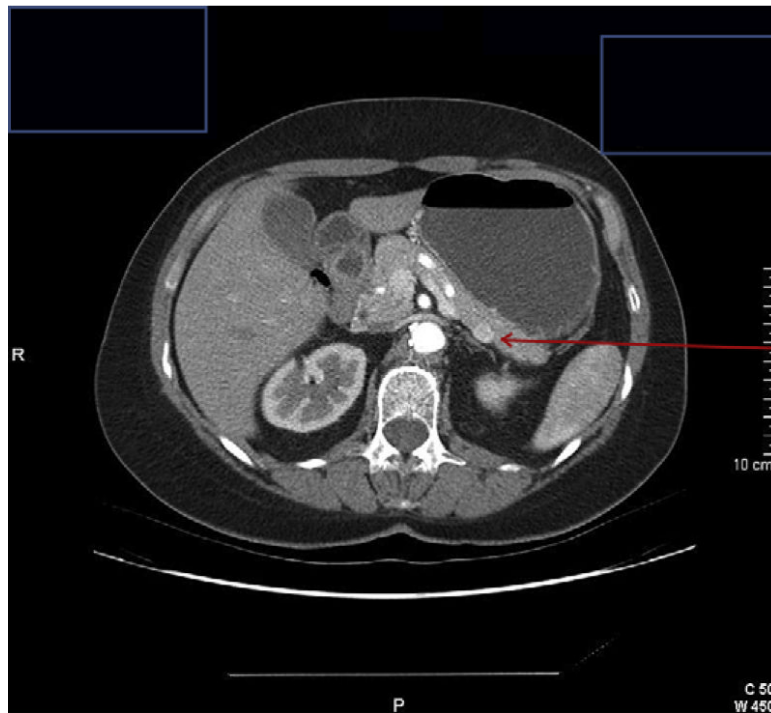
Lesion successfully localized by computed tomography scan. A round, well-circumscribed, hyperenhancing lesion can be seen at the tail of the pancreas (*arrow*). (*Courtesy of National Institutes of Health, Bethesda, MD.*)
